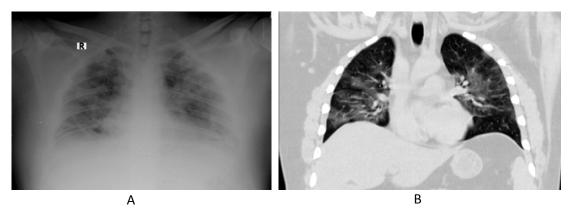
Chest X-ray (A) and CT (B) images of COVID-19 pneumonia. Ground-glass opacities in peripheral lung zones and in perihilar regions and focal consolidation in lower lobe of the right lung with surrounded GGO zone. Vascular dilatation is seen in both lower lobes.
